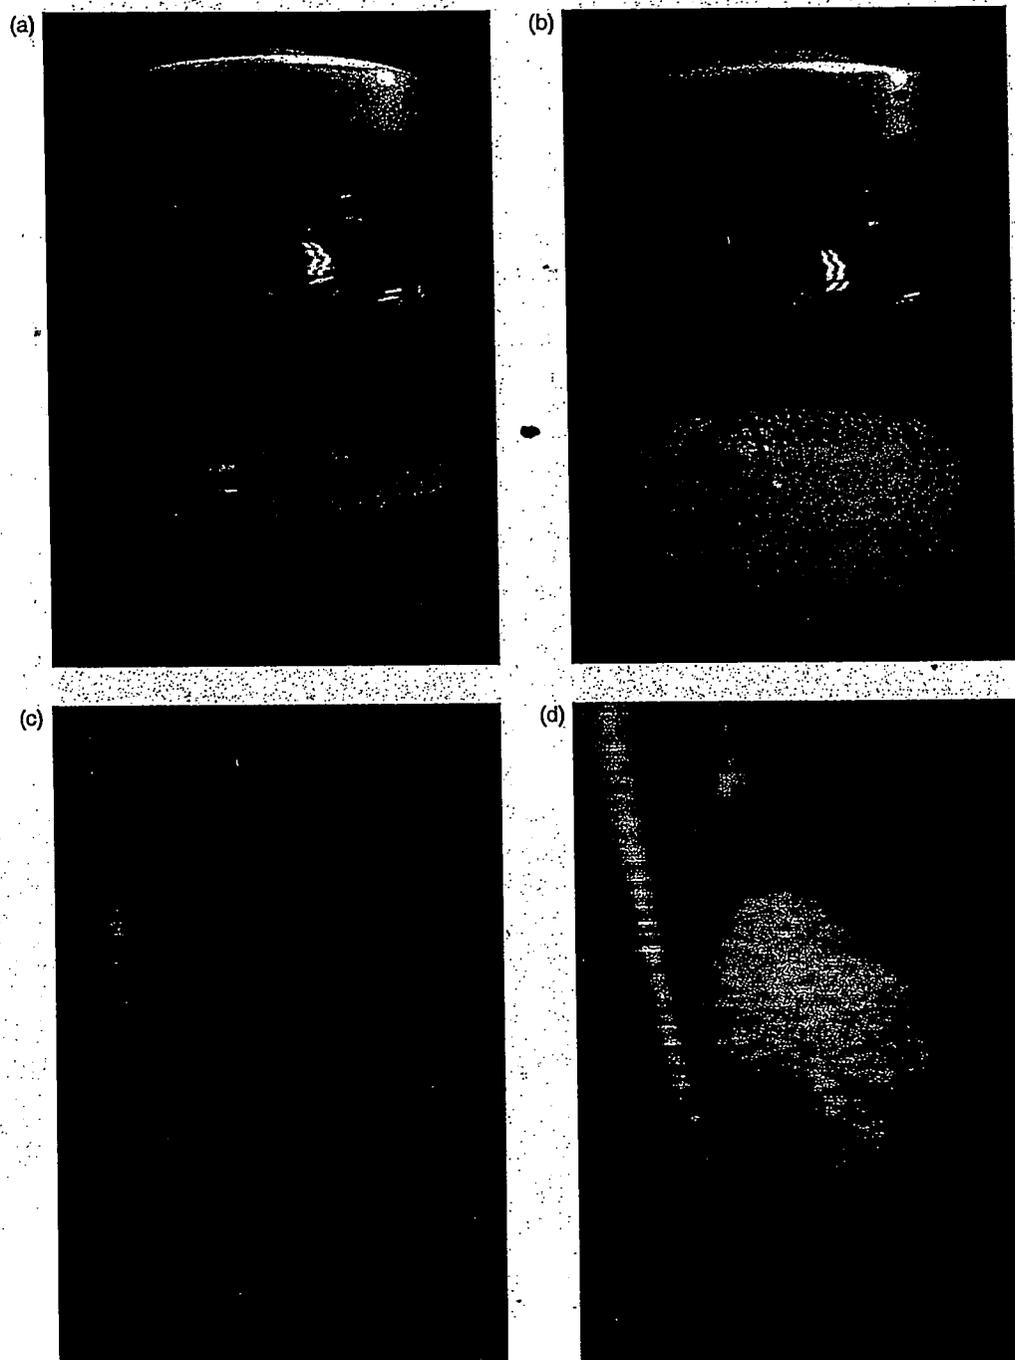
Aspect and ultrasonography of PEG-liposomes and Bubble liposomes. PEG-liposomes (a) were sonicated with supercharged perfluoropropane gas. After that, they became to Bubble liposomes (b). PEG-liposomes (c) and Bubble liposomes (d) were imaged with ultrasonography.
